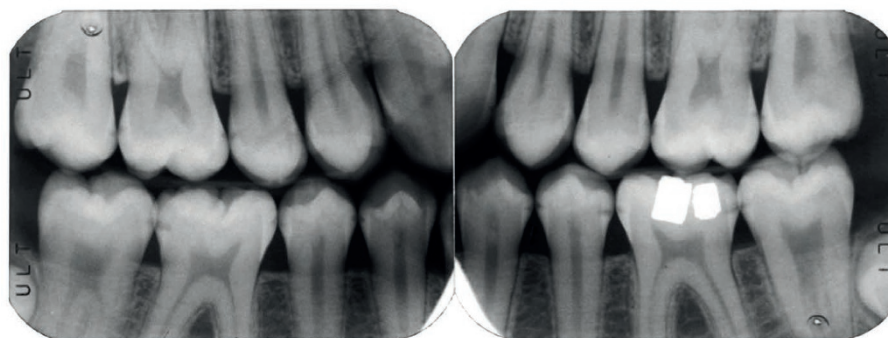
Bitewing radiographs showing multiple early lesions. Courtesy of Louis Mackenzie.
